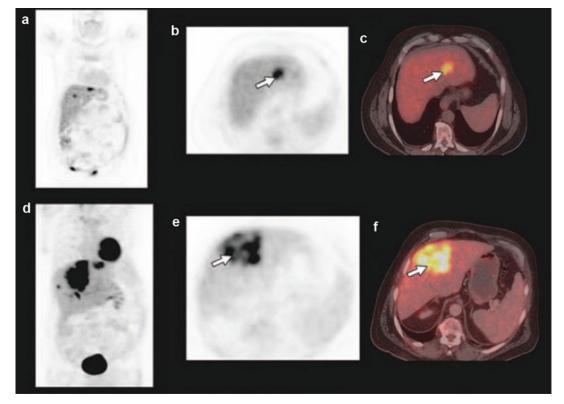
71-year-old man with history of sigmoid colon cancer with surgical resection and chemotherapy for 6 months. (a) Patient's carcinoembryonic antigen levels started increasing after 6 months, and [¹⁸F]FDG-PET/CT revealed hepatic metastasis. (b) Coronal PET shows two lesions (*arrow*) in segments 2 and 8. (c) Axial-fused PET/CT shows hypermetabolic lesion (*arrow*) in segment
